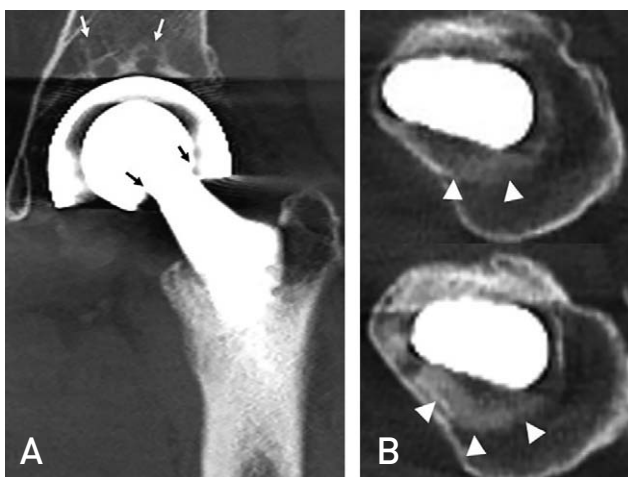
No remarkable abnormalities aside from subchondral cystic changes in the acetabulum (white arrows) were initially recognized on computed tomography images in April 2019; however, the cone of the stem did not coincide with the head center (black arrows) (A), and marked sclerotic changes around the proximal stem were noted retrospectively (white arrowheads) (B).
